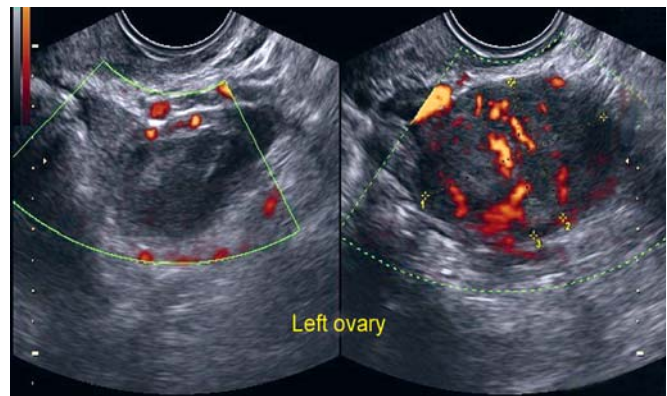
All solid lesions should be assessed with power Doppler. The presence of vascularity within a solid lesion confirms the presence of tissue and excludes fluid. This is a useful criterion for a neoplastic lesion. Occasionally, benign granulation tissue such as within an abscess may mimic this finding. A clinical perspective is therefore useful in the interpretation of these findings
